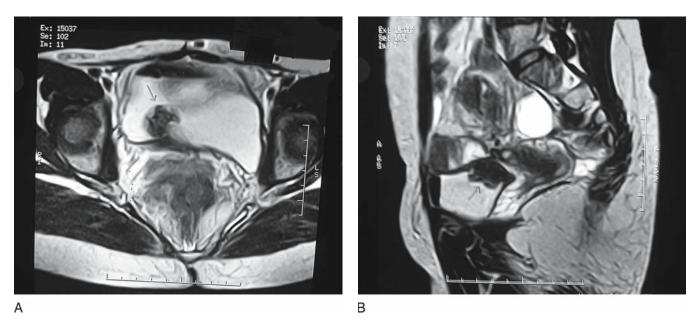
Magnetic resonance imaging (MRI) of the pelvis shows a polypoid mass (arrow) in the posterior wall of bladder; patient underwent two cesarean sections earlier
